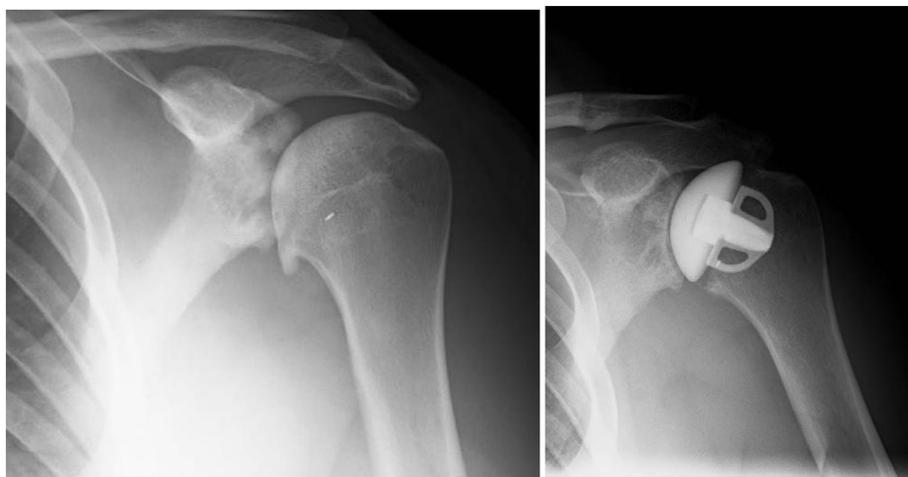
A and 1B – Pre and Post-operative radiographs of a 26 year old with instability arthropathy treated with stemless hemiarthroplasty and glenoid microfracture.
